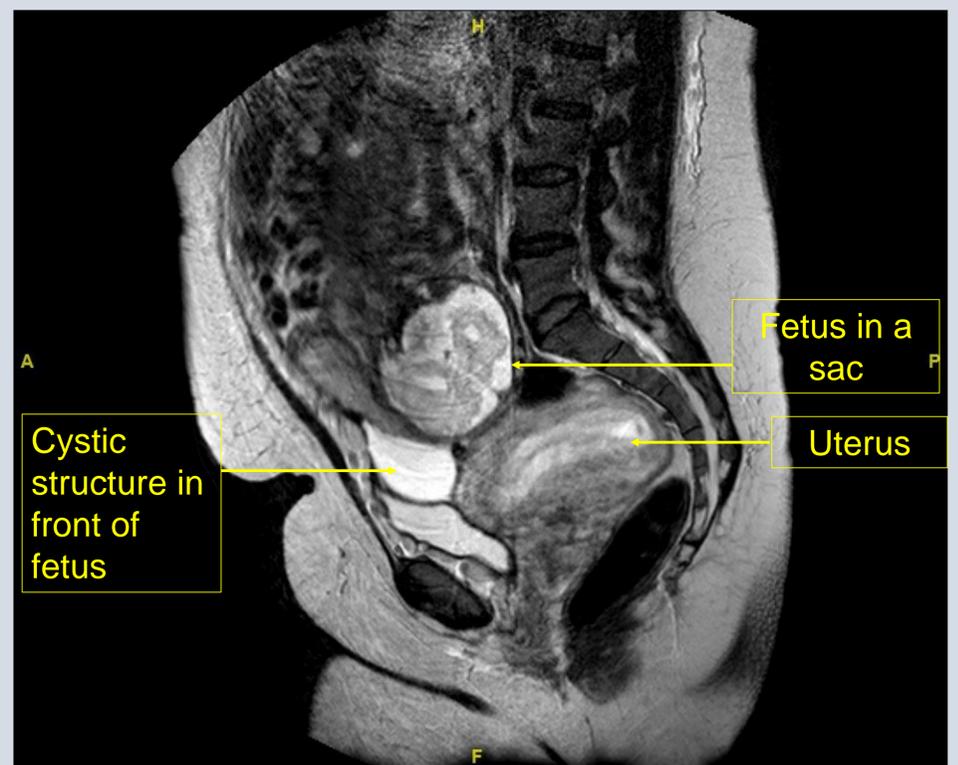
MRI at 30 weeks:
